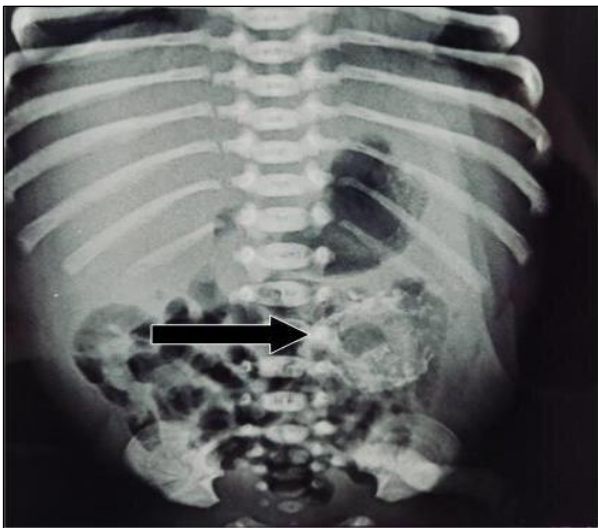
Plain supine abdominal radiograph calcified intra-abdominal lesion(black arrow) in left paraumbilical region.
